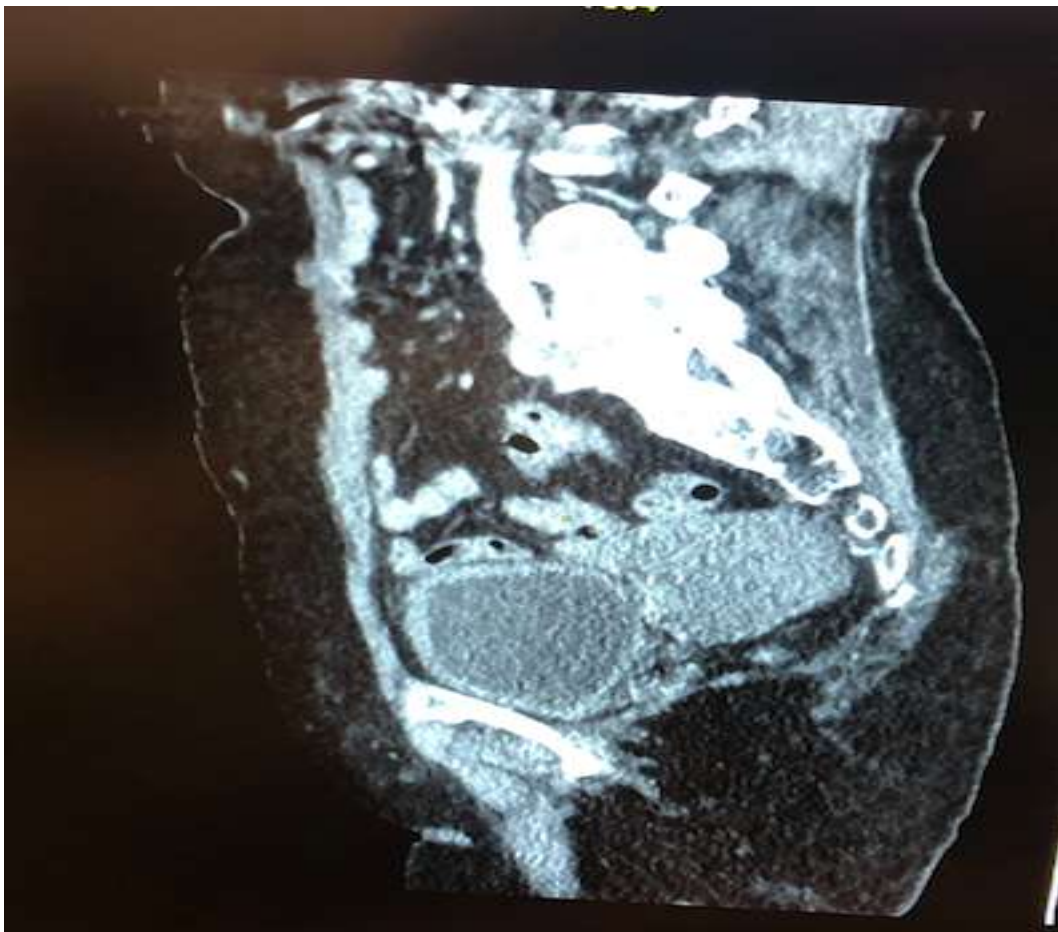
Contrast CT images of the tumor a) Sagittal image
